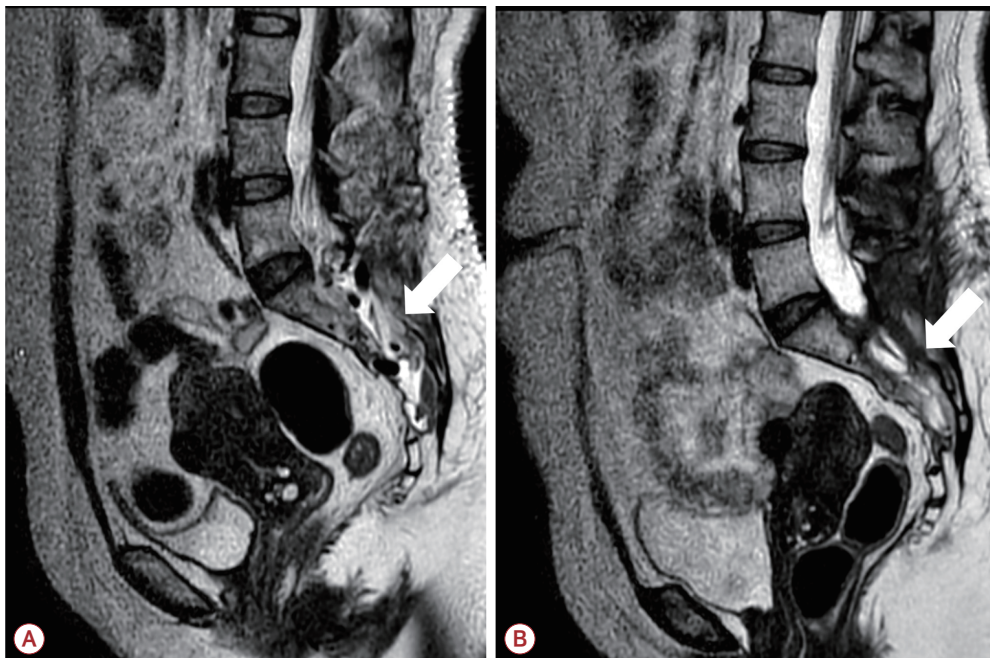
(A) Post-operative T2 sagittal images of the non-contrast lumbar spine MRI of a 52-year-old woman, taken three days after surgery, demonstrate complete removal of the meningeal cyst (white arrow). (B) The follow-up MRI taken 4 months after surgery revealed no recurrence of the meningeal cyst (white arrow). MRI; magnetic resonance imaging.
